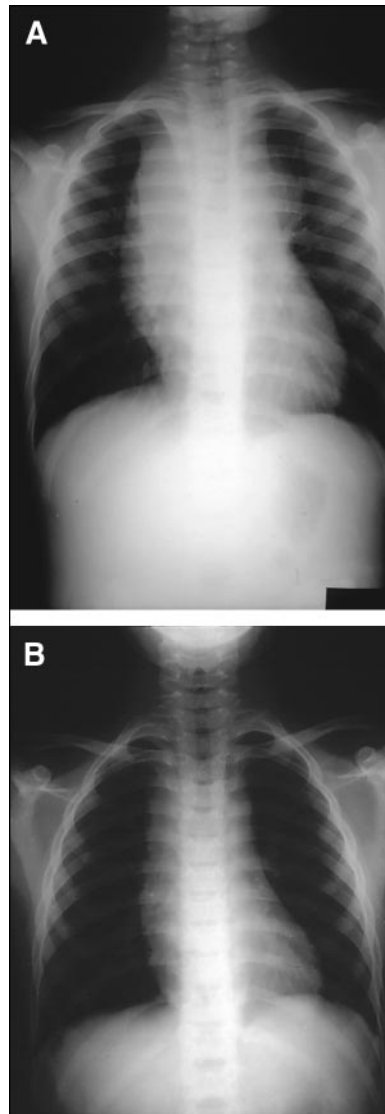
Patient *B* presented with shortness of breath and a complaint of tiredness for 2 to 3 weeks prior to diagnosis. The chest radiograph revealed a large mediastinal mass with deviation of the trachea (A). Tissue biopsy was consistent with HD. Although this patient also presented with respiratory complaints, the onset of clinical symptoms was indolent, which is more consistent with HD. After 4 weeks of treatment, chest radiography demonstrated a very good response, although widening of the mediastinum was observed (B).
